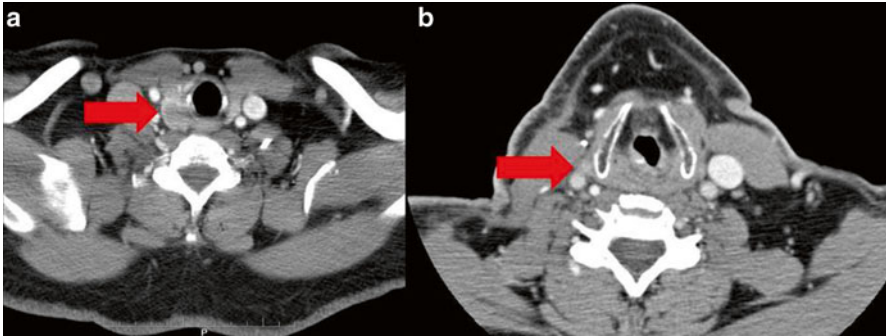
Staging CT images. (a) Preoperative CT, the *red arrow* indicated the mass in the right lobe of the thyroid. (b) A postoperative CT, the *red arrow* indicated the area of gross residual disease
